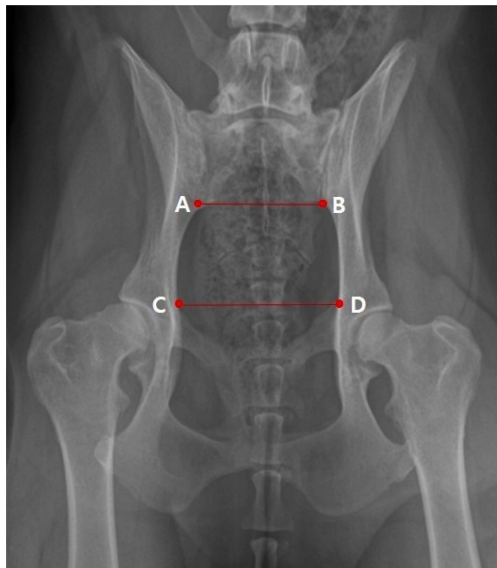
Dorsoventral radiograph of the pelvis and sacrum. Points “A” and “B” are on the right and left caudal part of the sacral wing, respectively. Points “C” and “D” are on the right and left cranial border of the acetabulum rim, respectively. Pelvic canal diameter ratio is defined as CD/AB. A normal pelvic canal diameter ratio is ≥ 1.1 .
